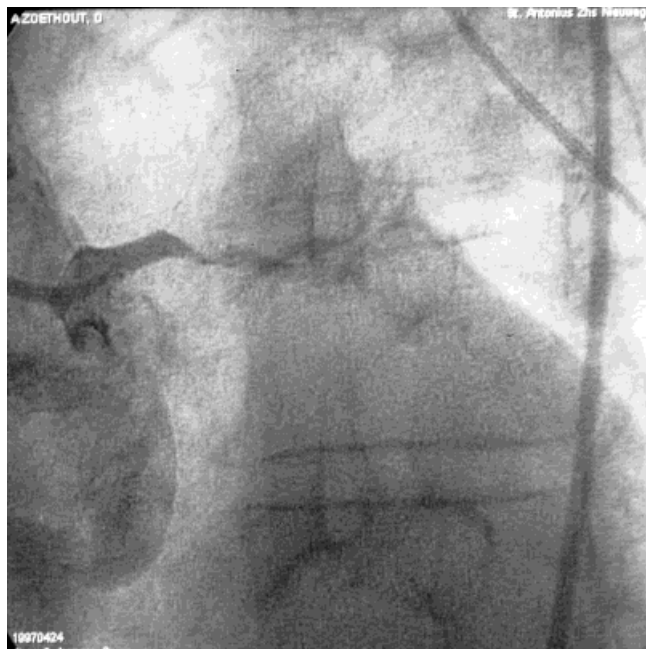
Subtotal occlusion of the left main coronary artery after a diagnostic intracoronary ultrasound study with very slow run-off into the circumflex artery and anterolateral branch. The left descending artery is not filling.
